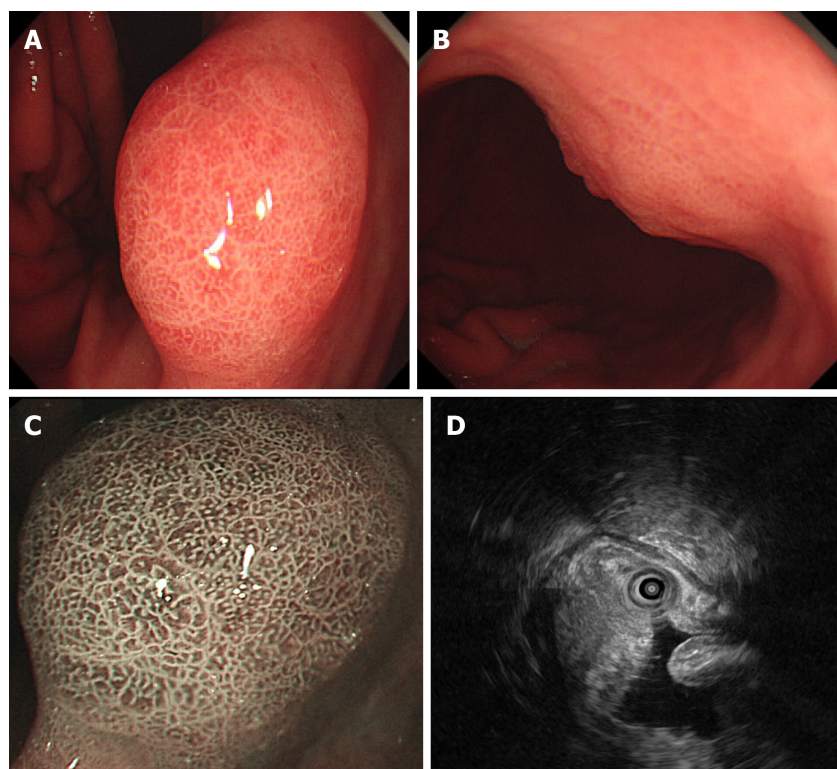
Endoscopic findings. A and B: A 1.6-cm type 0-Ia lesion covered by congested mucosa on gastric angle was observed by white light endoscopy; C: Regular microvascular pattern, presence of a demarcation line, irregular and smaller crypt opening, and widened intervening part were observed by magnifying endoscopy with narrow-band imaging. Magnification: 40×; D: Endoscopic ultrasound showed a 15.3 mm × 9 mm hypoechoic mass within the submucosal layer and thickened mucosal and submucosal layers.
